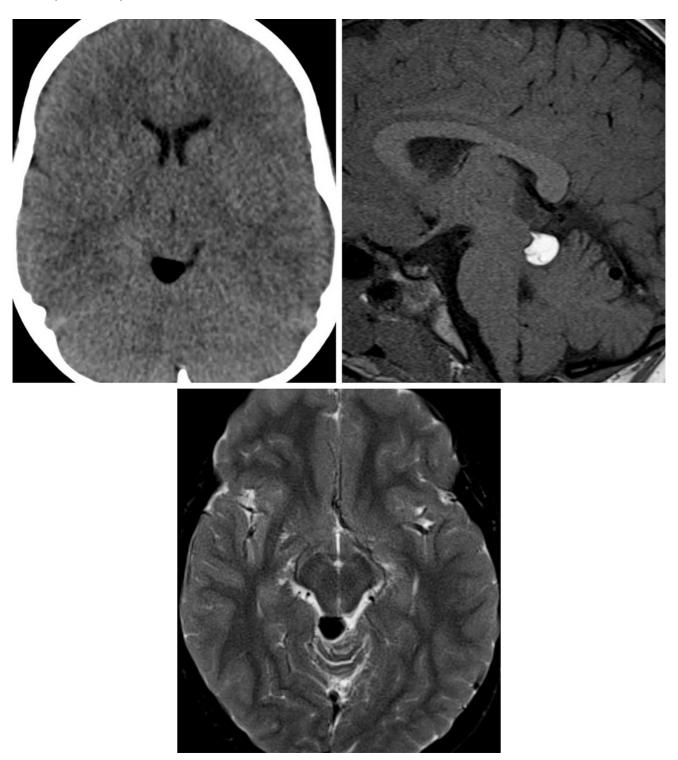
This tectal plate lipoma demonstrates low density of fat on CT imaging (top left) and hyperintensity on T1WI (top right). (Bottom) Fatsuppression techniques should make the lesion appear dark, as on this
